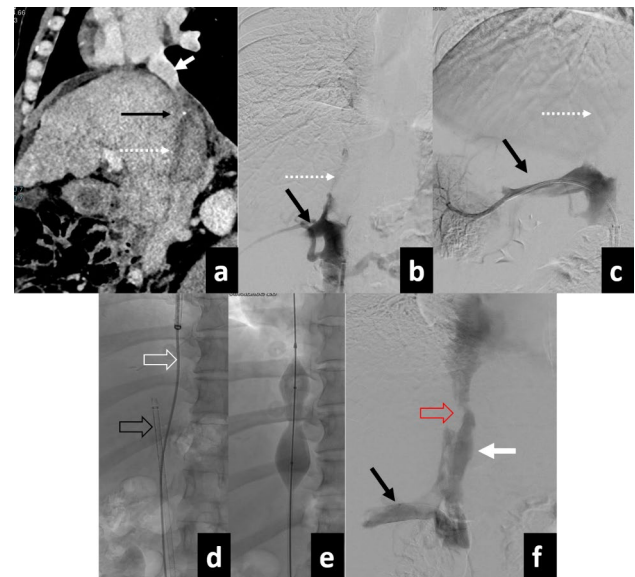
Transjugular IVC recanalization after a failed transfemoral approach. a Sagittal CECT showing a calcified (thin black arrow a) web within the intrahepatic IVC with proximal thrombus (dash white arrow a) and a patent suprahepatic IVC (short white arrow a); b, c Transfemoral venogram revealing intrahepatic IVC occlusion (dash white arrow b) with no forward flow to heart. A dominant right inferior accessory hepatic vein is also seen (black arrow b, c). d Following a failed transfemoral approach, stricture was negotiated after wedging an MPA (open white arrow d) catheter in the suprahepatic IVC through a transjugular route. e Balloon angioplasty was performed after crossing the obstruction. f Post-angioplasty venogram depicting recanalized IVC (thick white arrow f) with drainage of AHV (black arrow f). Although IVC was partially recanalized (open red arrow f), leg swelling improved after angioplasty, and the patient was kept on long-term anticoagulation *CECT* Contrast-enhanced CT, *IVC* Inferior vena cava, *MPA* Multipurpose angiographic catheter, *AHV* Accessory hepatic vein
